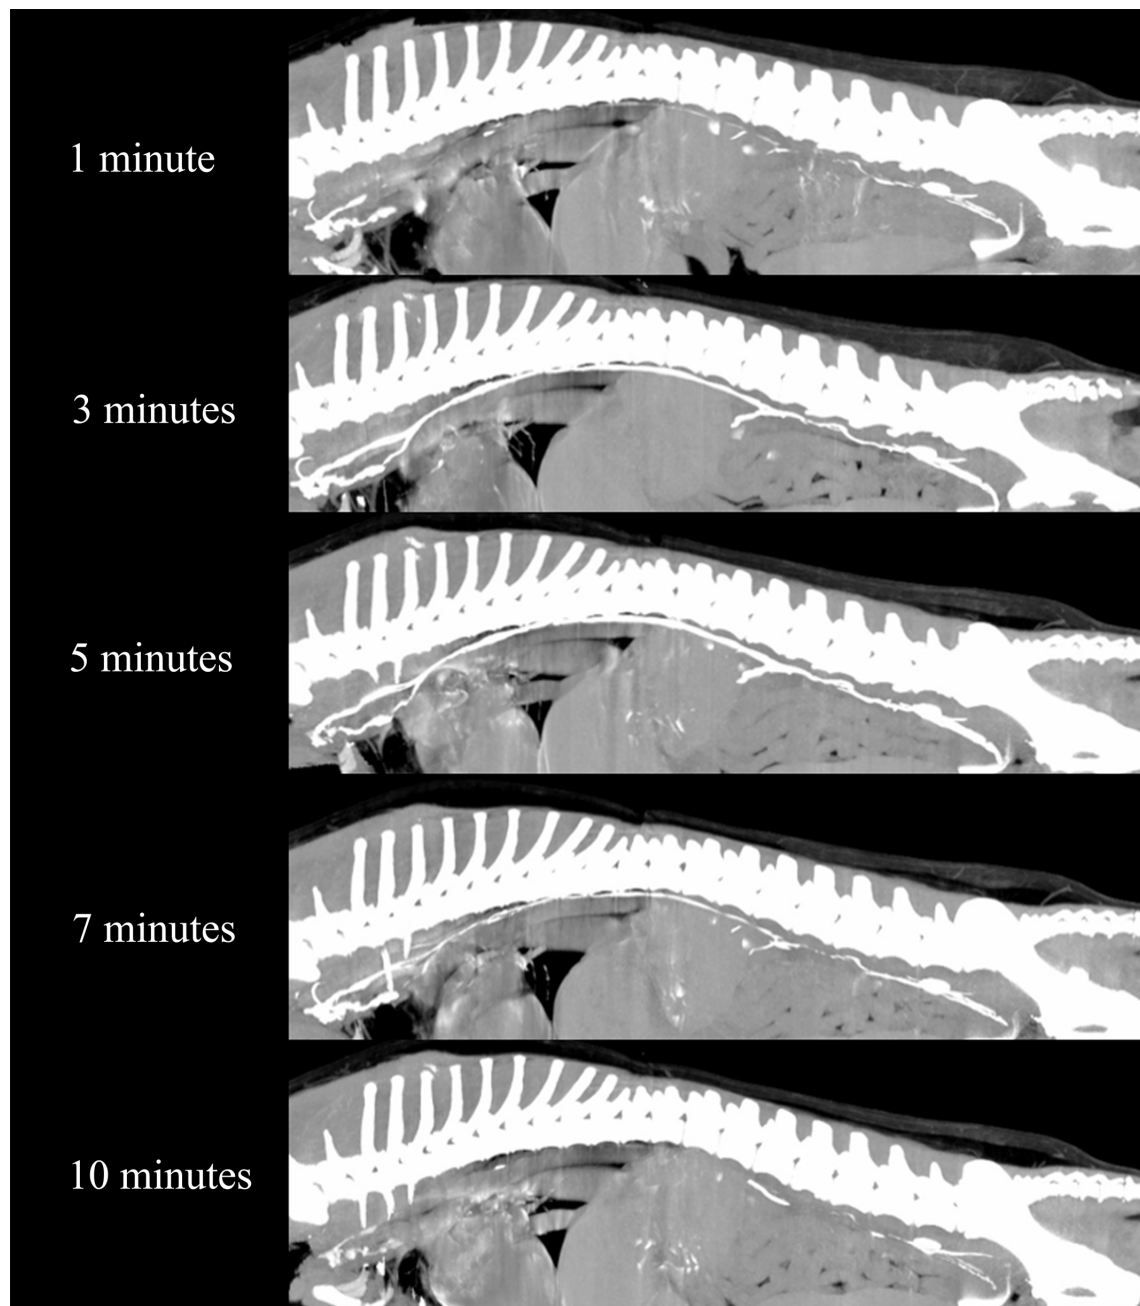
Maximum intensity projection (MIP) reconstruction CT images after CT lymphangiography with subcutaneous injection of contrast medium into the metatarsal region at the dose of 1 ml/kg. Images were obtained at 1, 3, 5, 7, and 10 minutes after injection. At 3, 5, and 7 minutes after injection, a well-enhanced thoracic duct and additional branches can be identified.
